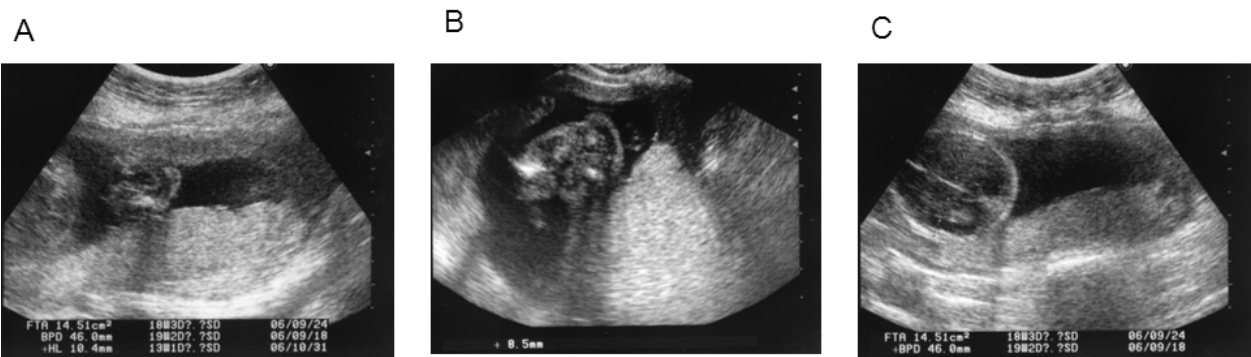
Ultrasonography examination at 19 weeks’ gestation of pl-HPP fetus
